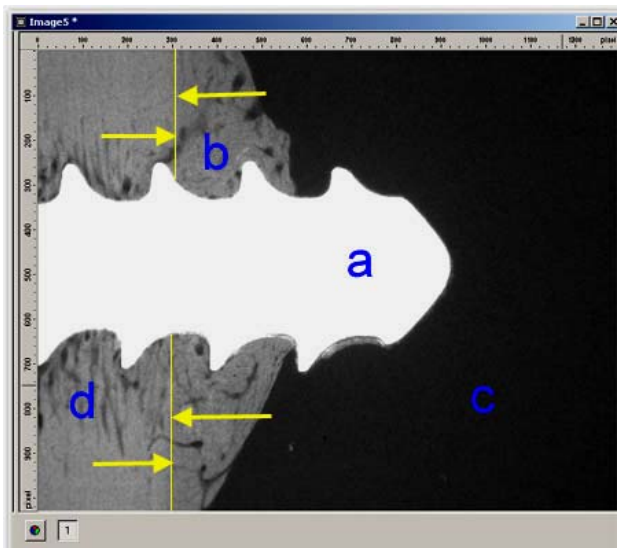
Contact radiograph image of a screw tip (a), callus formation (b), medullary canal (c) and original cortex (d) at week 12 post operatively. Yellow arrows mark the border between original bone and newly formed bone.
